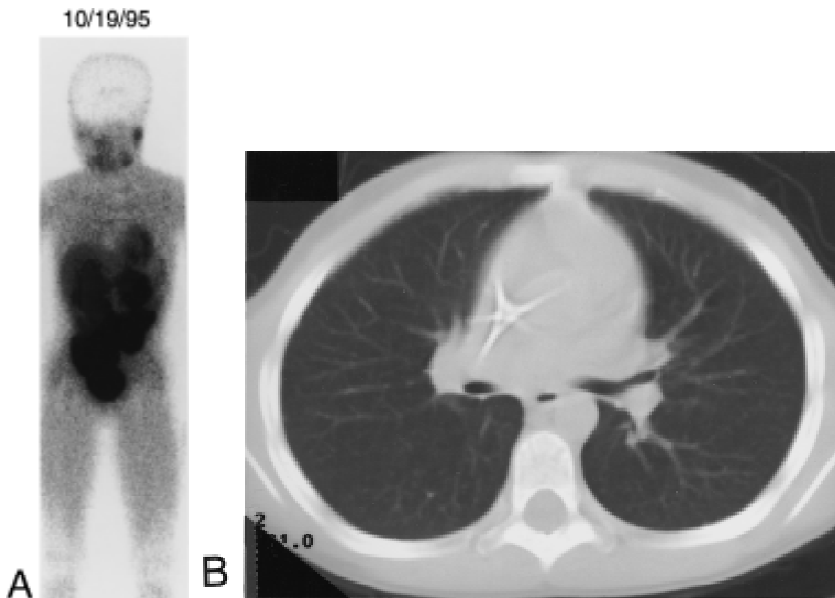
(A) ^{99m}Tc-sestamibi scan at radiographic remission. (B) Chest CT at radiographic remission.
